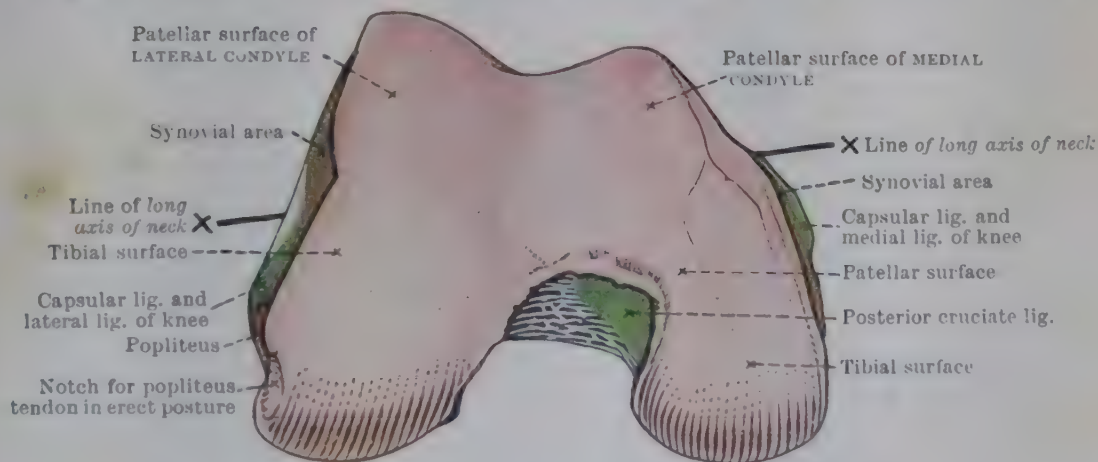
DISTAL ASPECT OF LOWER END OF RIGHT FEMUR.
